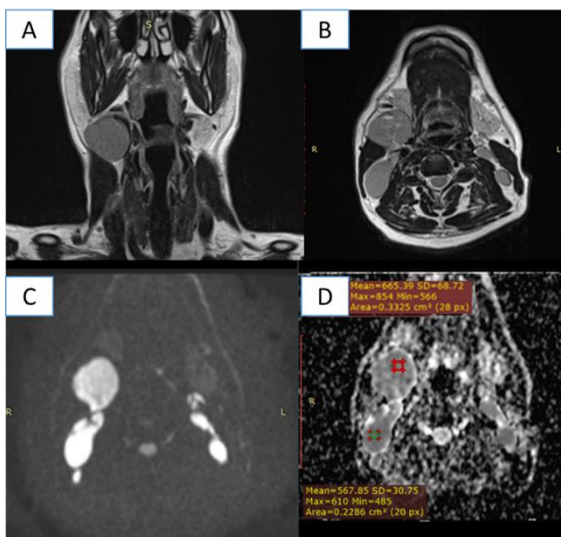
A 43-year-old male presented with bilateral palpable neck lymph nodes. A) Coronal view T2WI with B) Axial views MRI T1WI, C) DWI 1000
